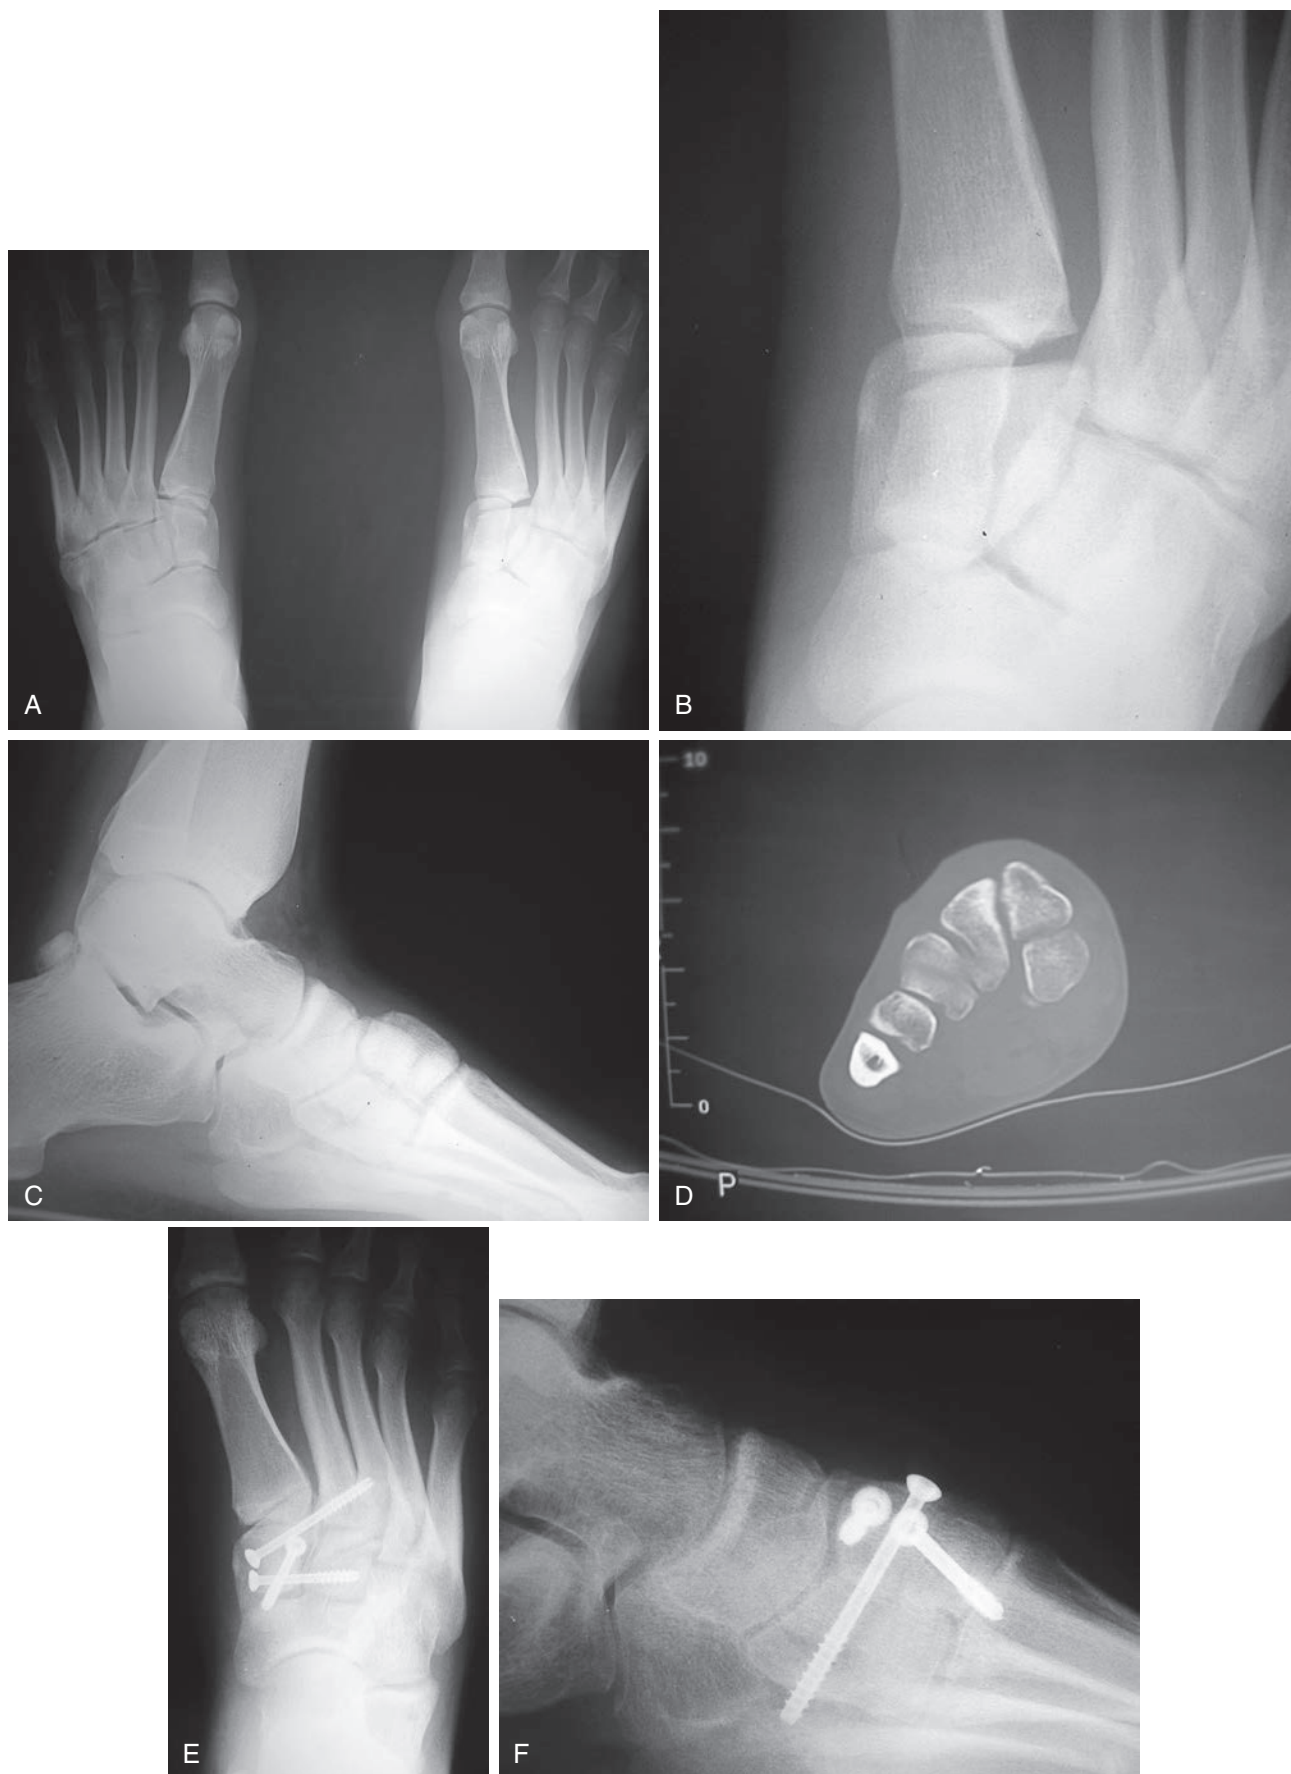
(A) Weight-bearing anteroposterior radiograph, with comparison, of a high school quarterback with acute midfoot injury. (B) Close-up suggests unusual arrangement in the area of medial cuneiform. (C) Lateral radiograph demonstrates separation of dorsal and plantar halves of medial cuneiform. (D) Computed tomography confirms bipartite tarsal bone. (E and F) Open repair requires attention to both the separated bipartite cuneiform with removal of synchondrosis and closure of the intermetatarsal diastasis, as well.
